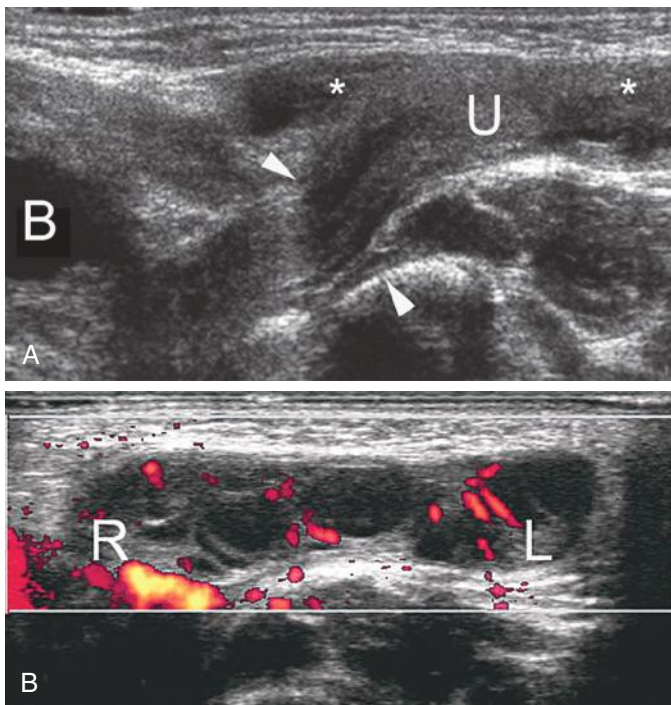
Incarcerated inguinal hernia in a 2-month-old girl. A, Transverse ultrasound image of the left groin shows the uterus (U) extending through a fascial defect (*between arrowheads*) into the soft tissues of the left labium majus. The uterus is interposed between the right and left ovaries (*asterisks*). B, bladder. B, Transverse power Doppler ultrasound image of the left groin demonstrates blood flow to both inguinal ovaries. An incarcerated indirect inguinal hernia was surgically reduced. L, left ovary; R, right ovary. See Video 34-6.
